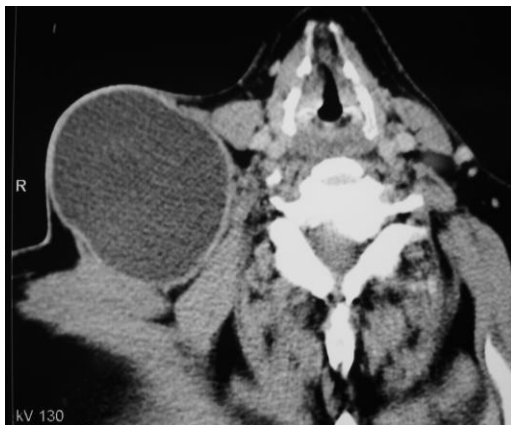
Axial computed tomography (CT) scan shows a welldefined, rounded, cystic mass.
